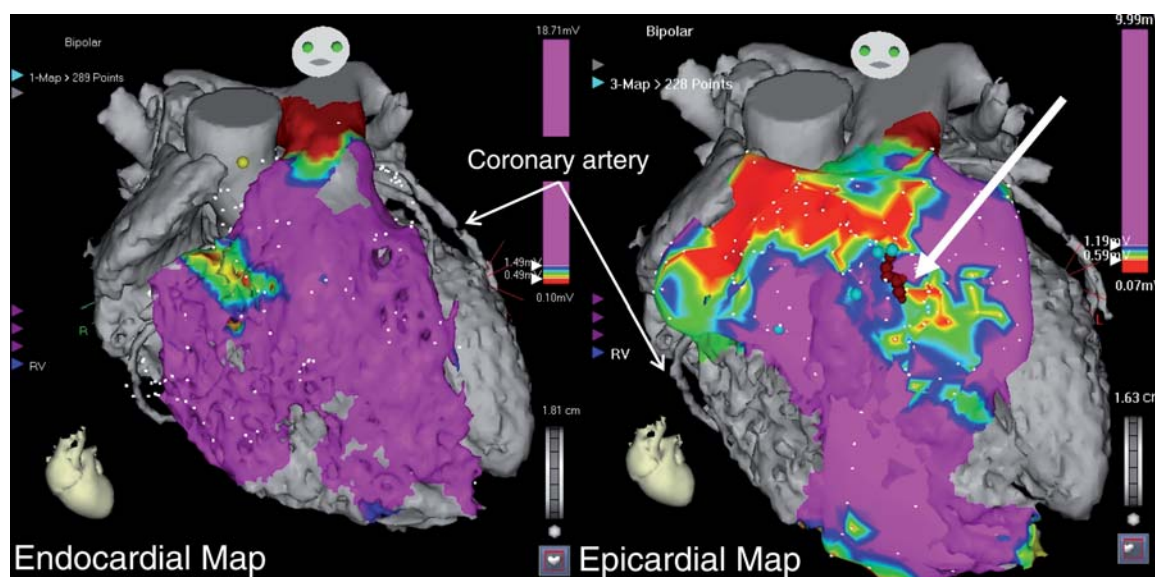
Three-dimensional voltage map in sinus rhythm performed with the CARTO system and merged with the cardiac CT scan, in a patient with right ventricular dysplasia and multiple shocks due to a repetitive unstable monomorphic sustained ventricular tachycardia (VT) refractory to antiarrhythmic medication. The VT circuit was epicardial (right panel) where the scar tissue was more extensive than in the endocardium (left panel). An ablation line was traced (arrow) closing a conducting channel, rendering the VT non-inducible.
